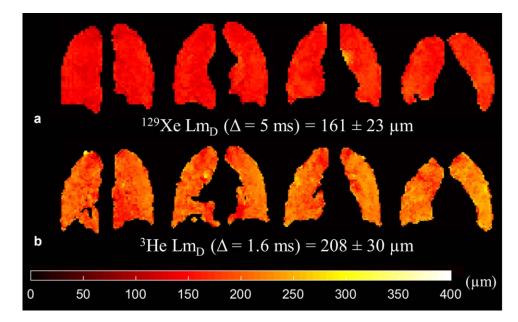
Prospective CS results for a healthy volunteer (HV1) (SNR = 30). (a) Example ¹²⁹Xe Lm_D maps derived from 3D multiple b-value ¹²⁹Xe DW-MRI. (b) Example ³He Lm_D maps in comparative slices demonstrate the mismatch in Lm_D values between the two nuclei.
